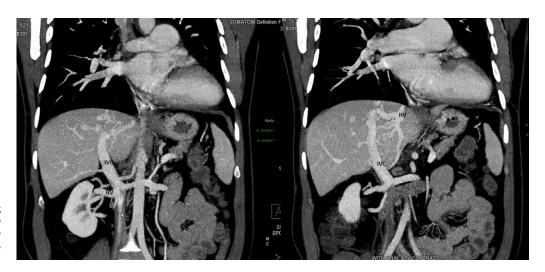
CT angiogram depicting absent intra-hepatic segment of the inferior caval vein and continuation to RA by hepatic veins, RV = renal vein, HV = hepatic vein.
